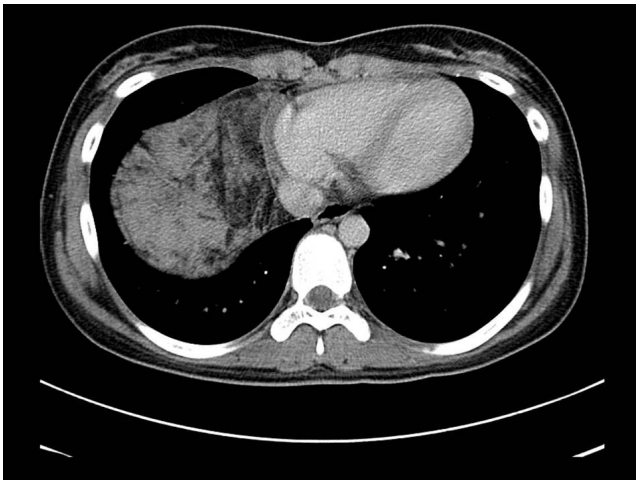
Preoperative chest computerized tomography. Contrast enhanced CT shows mediastinal soft tissue mass with internal fat content from anterior mediastinum, extending along the right cardiac border and right diaphragm.
